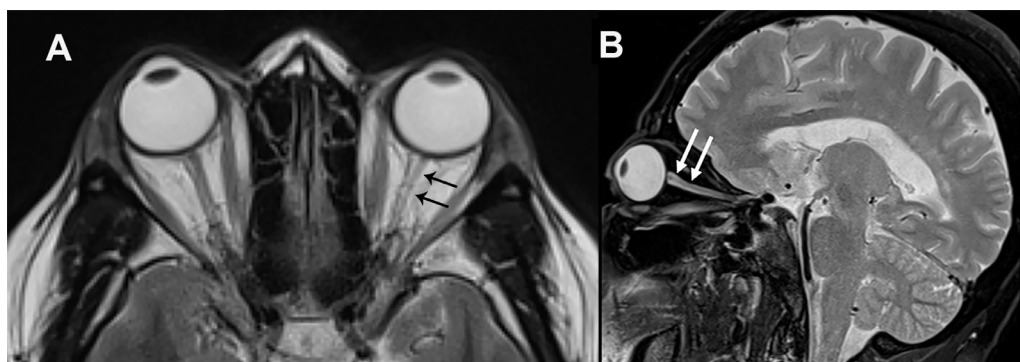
MR images of the orbits. (A) Axial T2-weighted image (repetition time msec/echo time msec, 6000/60) shows small caliber of left optic nerve (black arrows) in comparison to the right optic nerve. (B) Sagittal fat-suppressed T2-weighted image (3000/66) through the left orbit shows small caliber of left optic nerve and increased fluid signal within the perioptic nerve sheath (white arrows).
